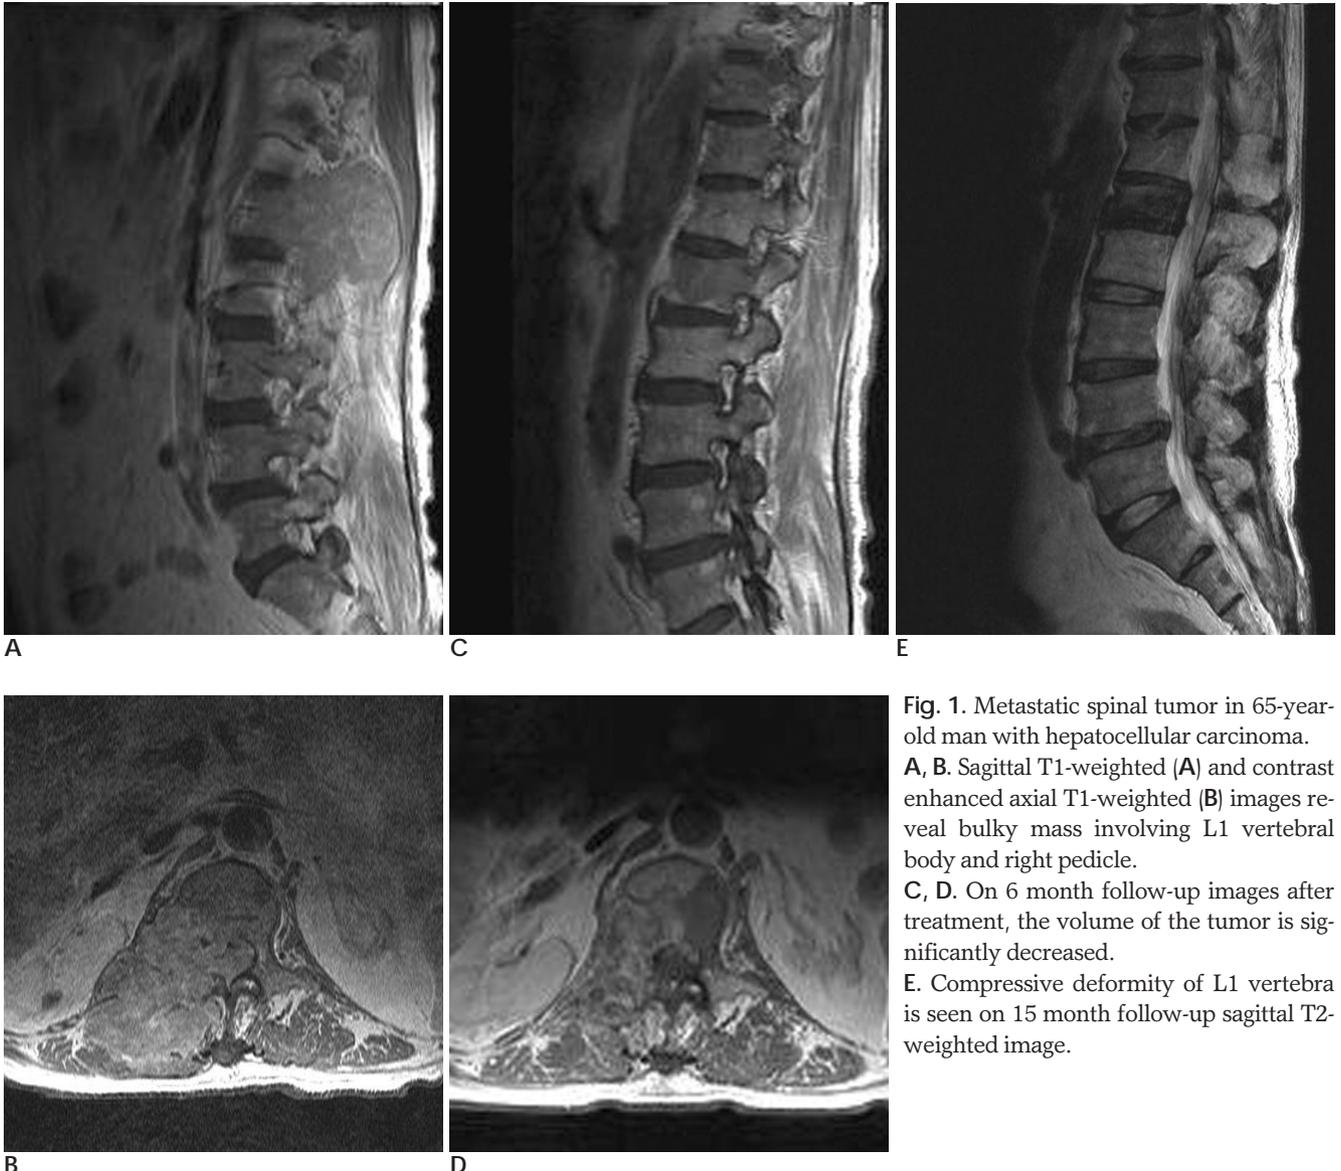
Metastatic spinal tumor in 65-year-old man with hepatocellular carcinoma. A, B. Sagittal T1-weighted (A) and contrast enhanced axial T1-weighted (B) images reveal bulky mass involving L1 vertebral body and right pedicle. C, D. On 6 month follow-up images after treatment, the volume of the tumor is significantly decreased. E. Compressive deformity of L1 vertebra is seen on 15 month follow-up sagittal T2-weighted image.
